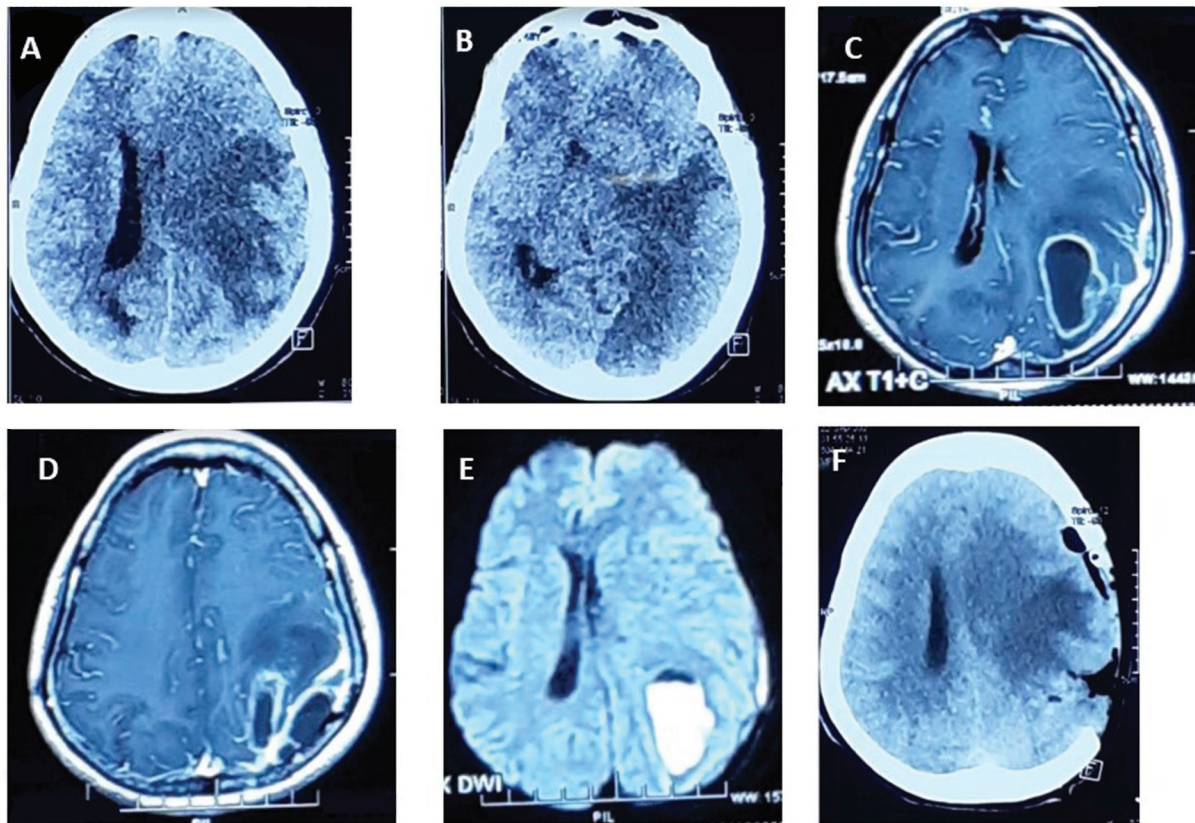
(A) Preoperative computed tomography showing hypodense space-occupying lesion present in the left parietal region with significant perilesional edema and midline shift toward left. (B) Preoperative computed tomography brain showing developing infarct in left posterior cerebral artery territory. (C) Preoperative magnetic resonance imaging brain showing ring enhancing lesion present in the left parietal region. (D) Preoperative contrast-enhanced magnetic resonance imaging brain showing presence of extradural collection in left parietal region with enhancement of the dura. (E) Preoperative diffusion-weighted image showing presence of diffusion restriction within the lesion. (F) Postoperative computed tomography brain showing complete evacuation of the abscess cavity. Parietal craniectomy defect present.
